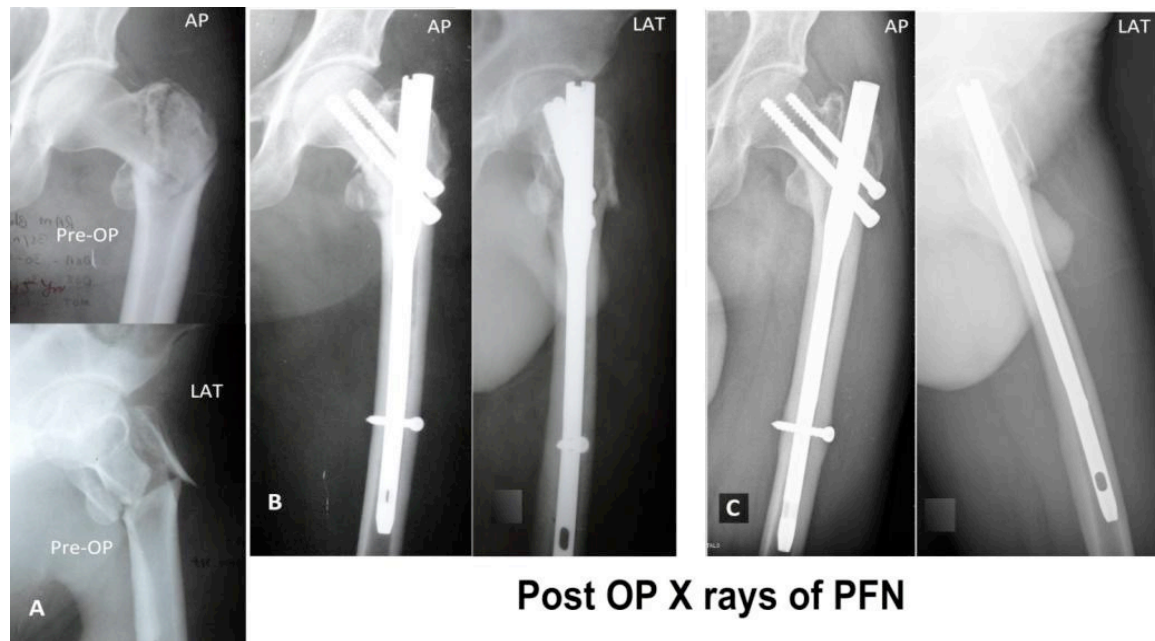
Radiographs of a 40-year old man with an A2-type trochanteric fracture: (A) pre-operatively; (B) 4 months after the operation; (C) 1 year after the operation
